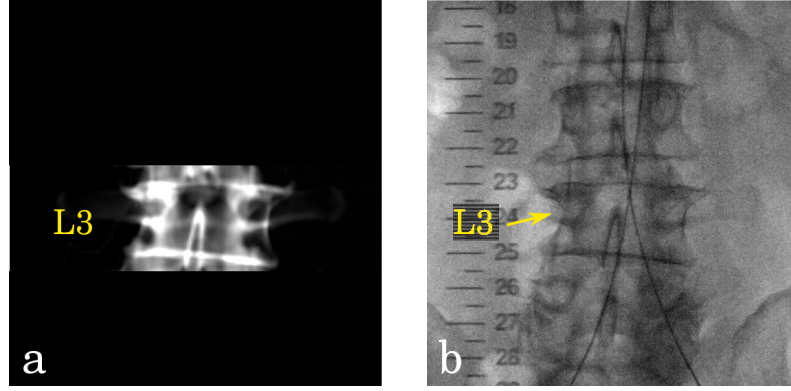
a) Digitally reconstructed radiograph (DRR) of an automatically segmented L3 vertebra from the preoperative CT volume of a patient undergoing EVAR. b) Fluoroscopy image of the same patient for the abdominal region with the L3 vertebra indicated.
